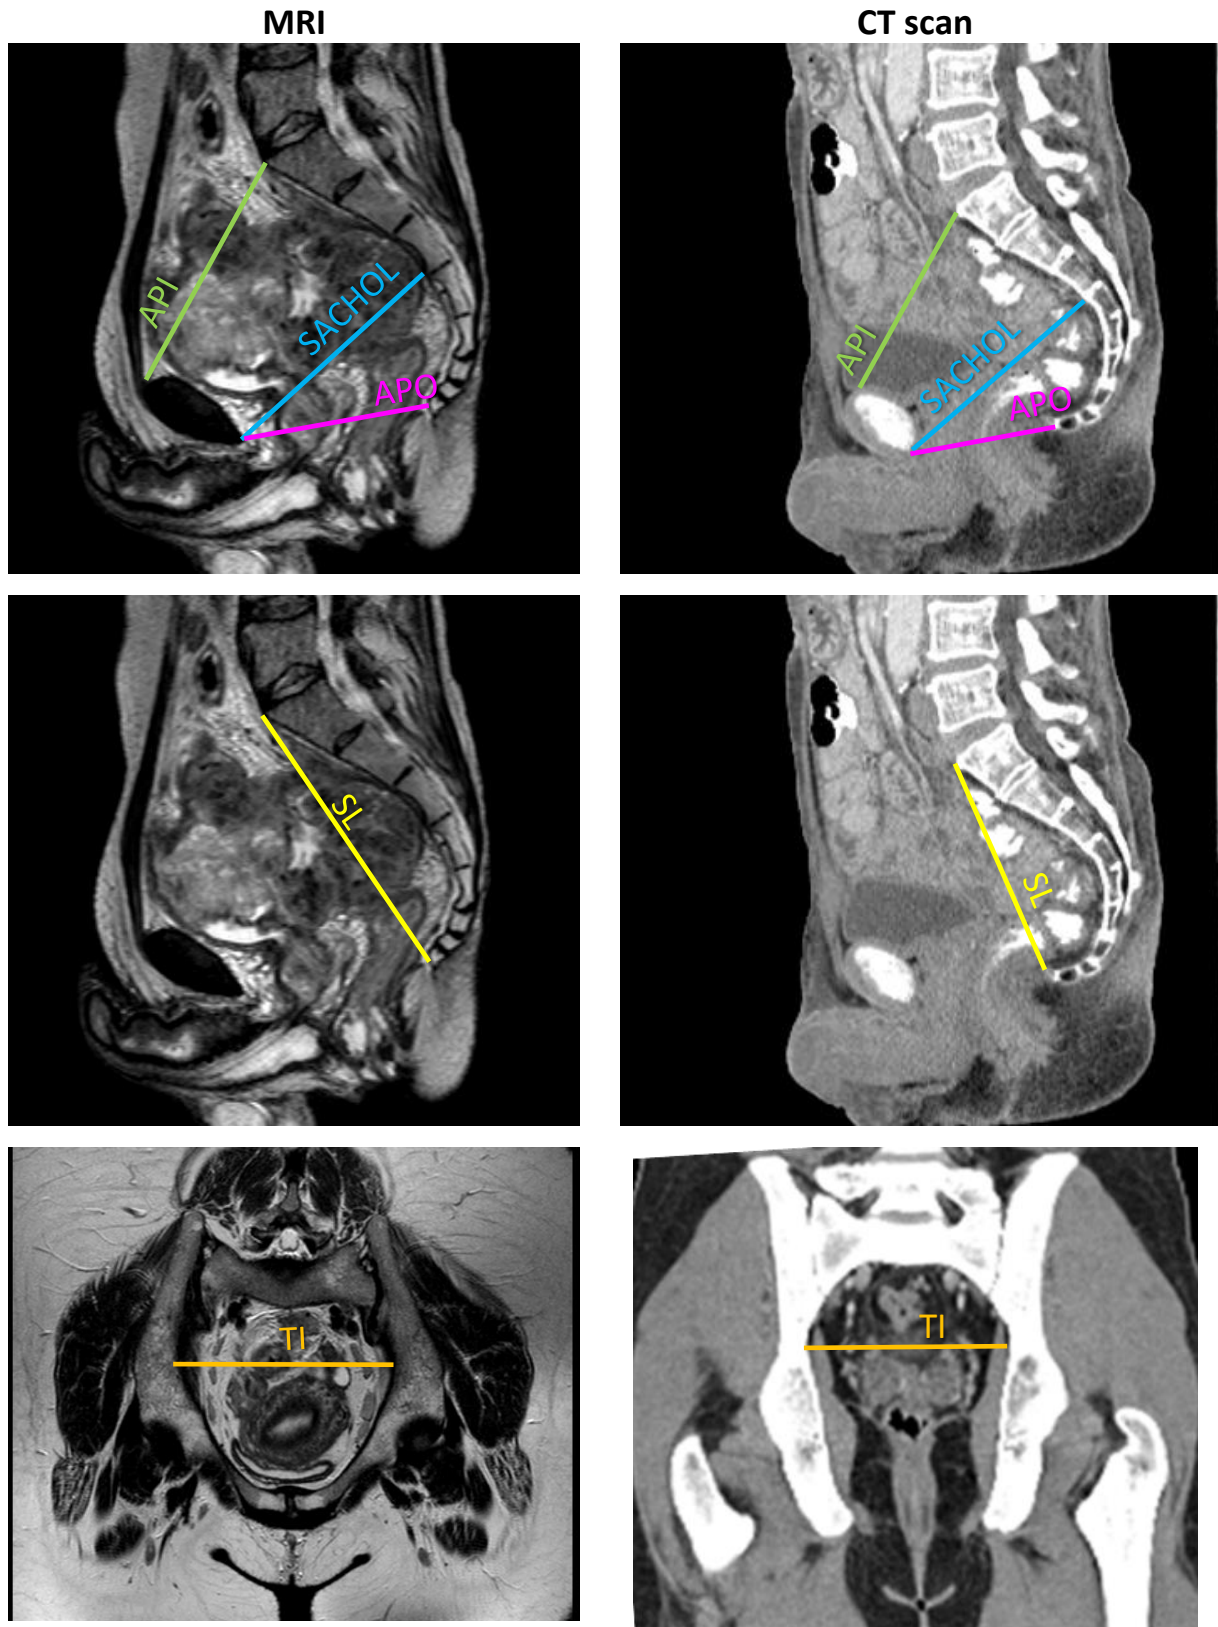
Comparison of measurements taken on MRI (left) and CT scan (right) (different subjects)
